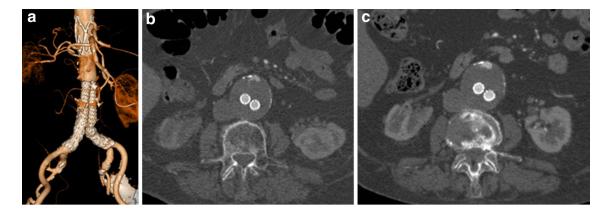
Volume rendering reconstruction of a CT scan performed during follow-up in a patient with Ovation stent graft (a); CT scan performed after 1 year revealed type 2 endoleak (b); type 2 endoleak and the diameter of the sac remained stable (c)
